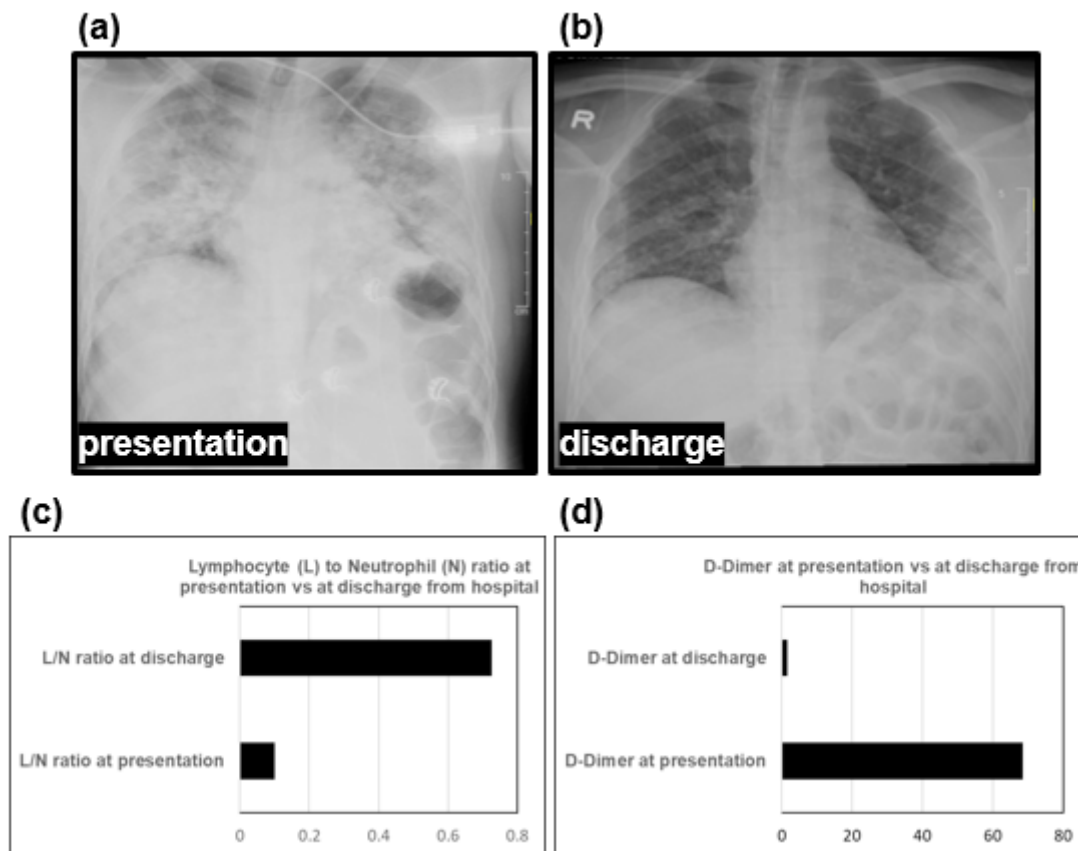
Chest X-ray and laboratory investigations (neutrophils, lymphocytes and D-Dimer) at presentation vs at discharge from hospital: a) Portable chest X-ray images at presentation showing extensive bilateral air space disease vs b) significant improvement at discharge. c) laboratory investigations for lymphocyte (L) and neutrophil (N) showing a very low ratio indicating severity of the disease at presentation vs high ratio indicating clinical improvement at discharge d) laboratory investigations for D-Dimer showing very high level at presentation vs a very low level at discharge.
